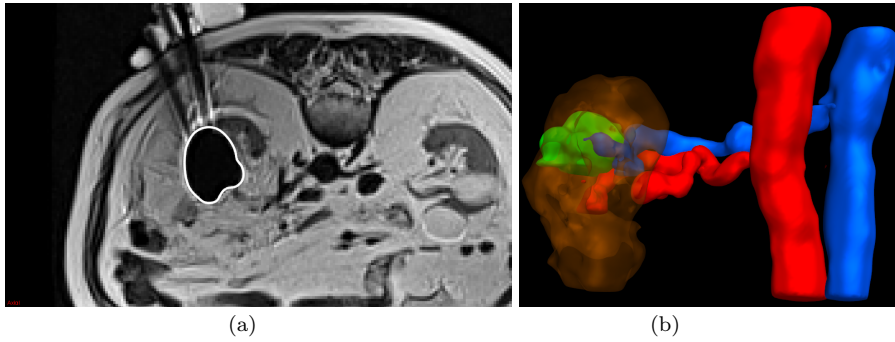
Intraoperative MRI scan validation. (a): representative MRI slice with the superimposed iceball contour (white); (b): visualization of the structures of interest after segmentation: kidney (brown), tumor (green), artery (red) and vein (blue).
